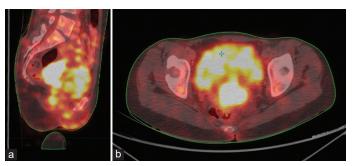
Initial positron emission tomography-computed tomography images showing fludeoxyglucose-avid lesion in the cervix (SUV-11.6) with bilateral common iliac and external iliac nodes (SUV-6.2) (a) sagittal view, (b) axial view
